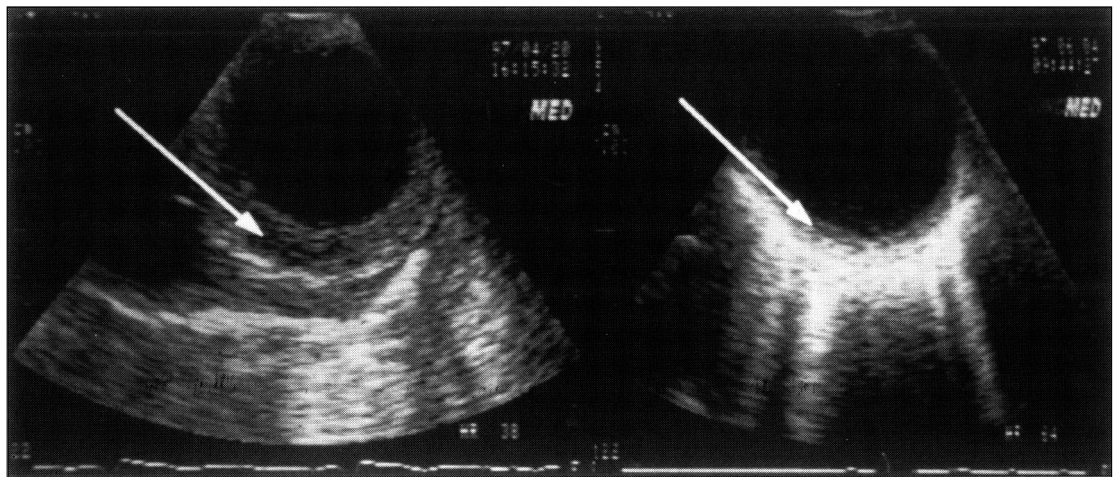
Transesophageal echocardiography at the level of abdominal aorta in patients with type aortic dissection shows intramural hematoma(left arrow) and much resolved intramural hematoma(right arrow) in 1.5 months.
